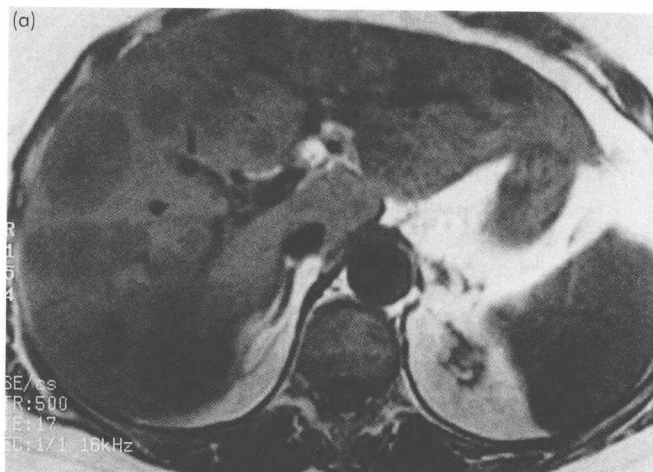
Magnetic resonance imaging (MRI) scan of the liver demonstrating multiple metastases as low signal on (a) T1-weighted and high signal on (b) T2-weighted images.
